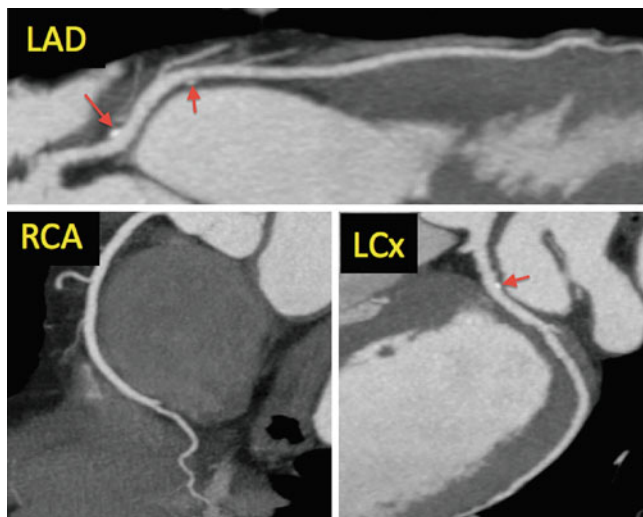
Coronary CT angiogram depicting mild, non-obstructive calcified plaque in the proximal and mid-LAD and proximal LCx (red arrows). The RCA and PDA appear widely patent and are free of coronary atherosclerosis. LAD left anterior descending coronary artery, LCx left circumflex coronary artery, RCA right coronary artery, PDA posterior descending coronary artery
